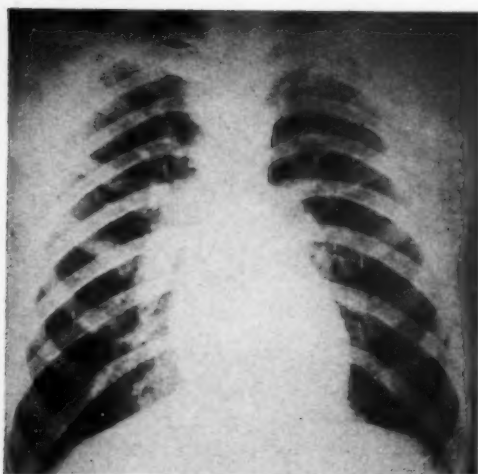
Case 1 (A. D.): Roentgenogram two days after admission, showing hilar adenopathy without parenchymal involvement.
